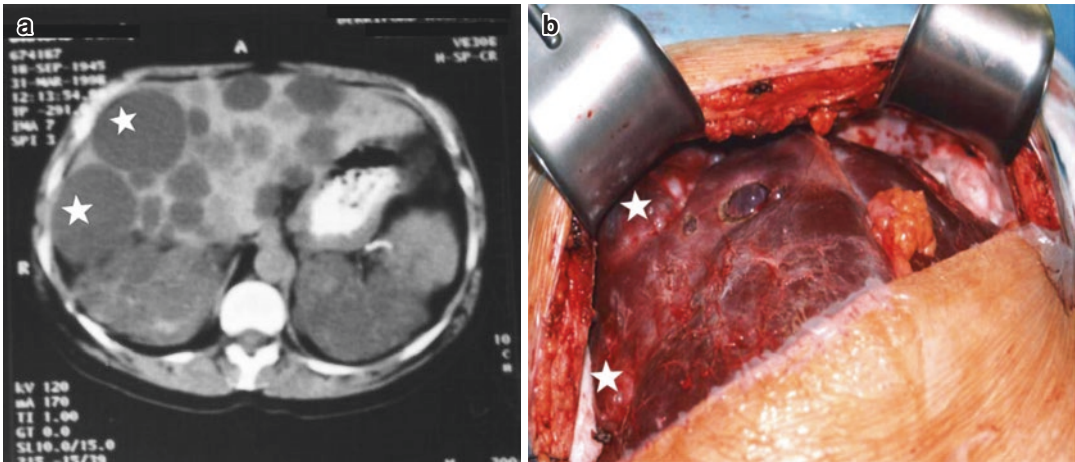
Axillar CT section (a) with multiple liver cysts (stars) and the appearance of cysts in our patient who underwent laparotomy for unroofing (b)
